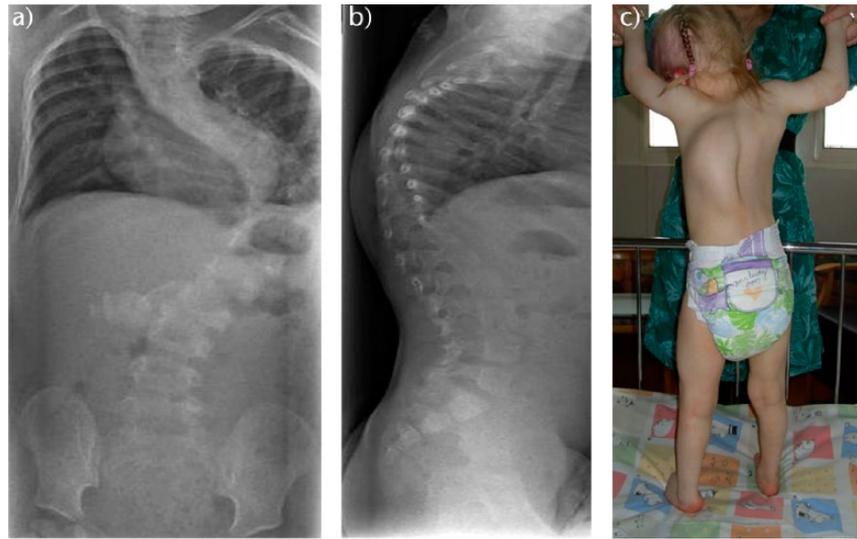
Two-year-old girl with severe thoracic early-onset scoliosis: a) and b) standing posteroanterior and lateral spinal radiographs; c) clinical photograph demonstrating major rib hump and deformity.
